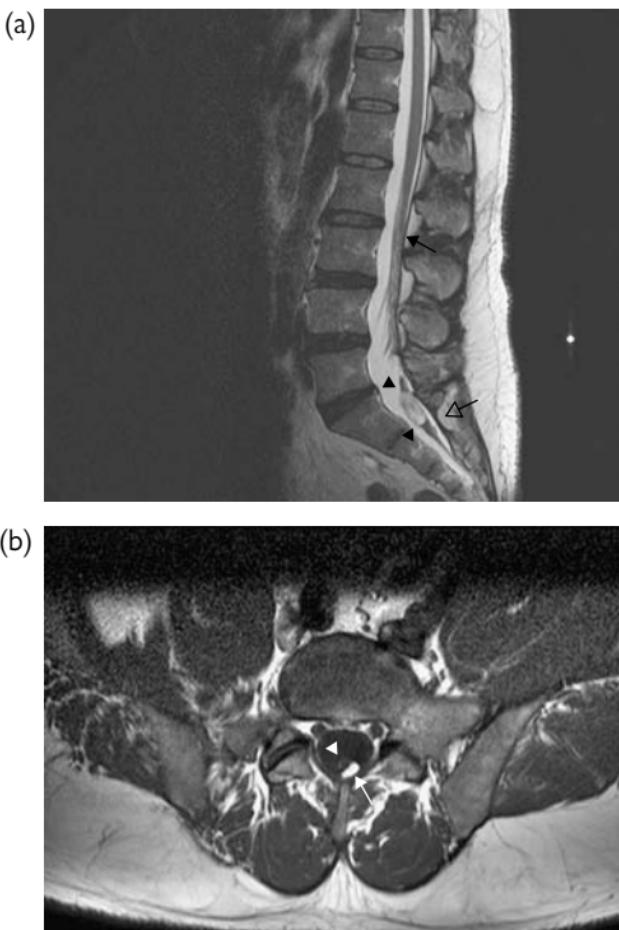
Spinal dysraphism. (a) Sagittal T2W and (b) axial T1W MRI. The termination of the spinal cord is low lying at the upper border of L3 (black arrow) and an intradural ovoid mass at S1 ((a) black arrowheads; ((b) white arrowhead) contains fatty elements ((b) white arrow) representing an intradural dermoid inclusion body. Note deficiency of the posterior elements of the second sacral segment ((a) open black arrow).
